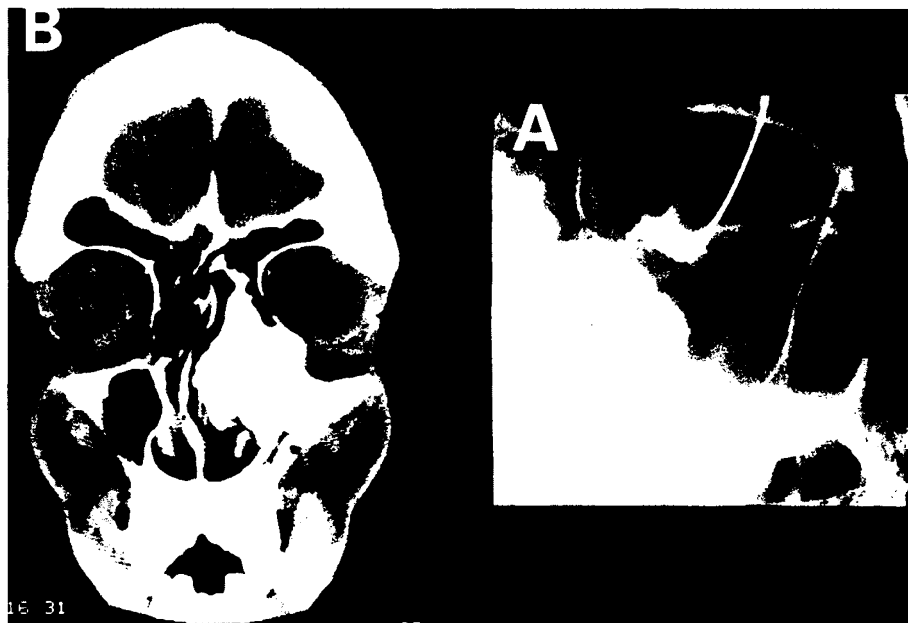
(A) A left dacryocystogram showing a large mass along the medial orbital wall displacing the nasolacrimal duct and resulting in a secondary mucocoele and dilatation of the canaliculi. (B) A CT dacryocystogram confirming the mass as a tumour arising from the ethmoid sinuses.
